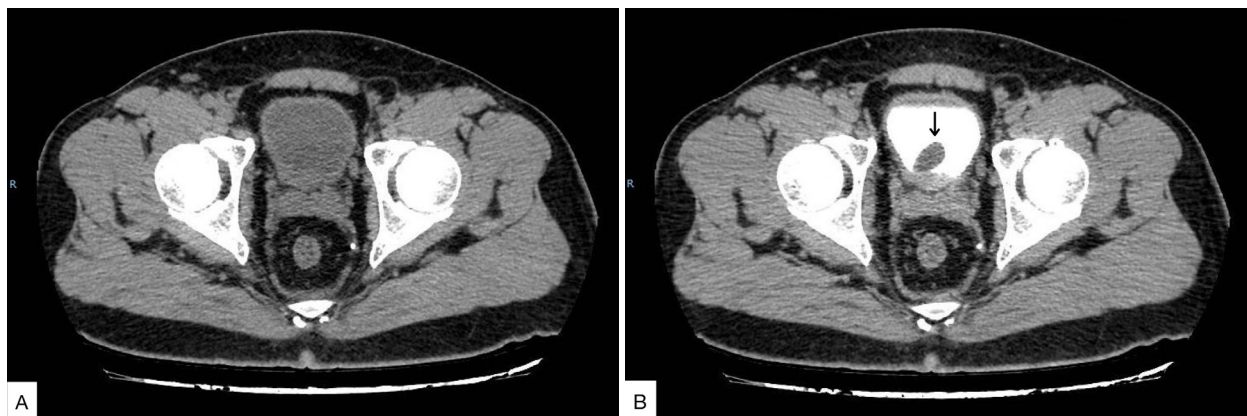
CT scans post contrast (A) and delayed phase (B) show Brunn's cyst (arrow).
